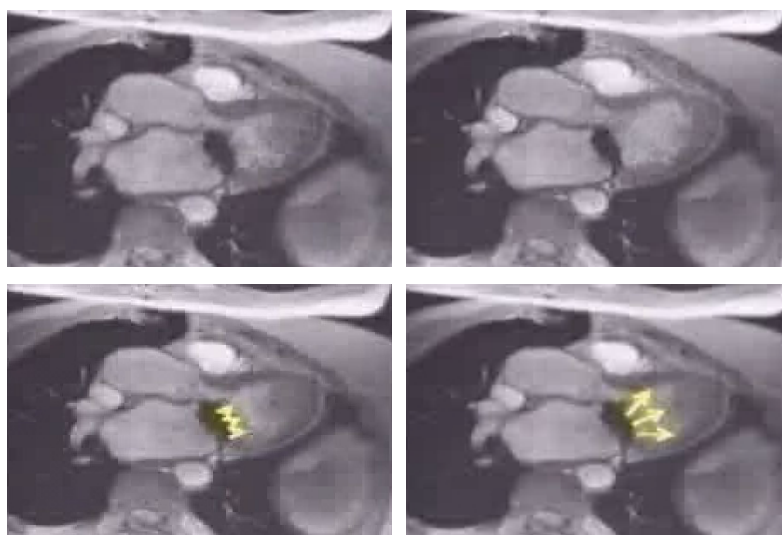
MRI images showing the loss of asymmetric redirection after implantation of a bileaflet MHV. (Laas et al., 2000)
